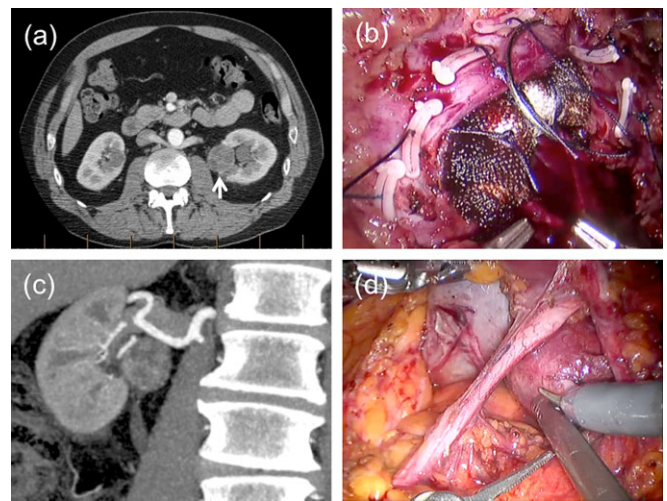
(a) Computerized tomography section demonstrating a left posterior hilar tumour (arrow) that was removed during an extended warm ischaemia time (50 min). This was the second of staged bilateral robotic-assisted partial nephrectomy (note contralateral endophytic tumour). (b) Computed tomography demonstrating a hilar tumour; (c) dissection of a difficult hilar tumour; (d) closure of a hilar tumour.
